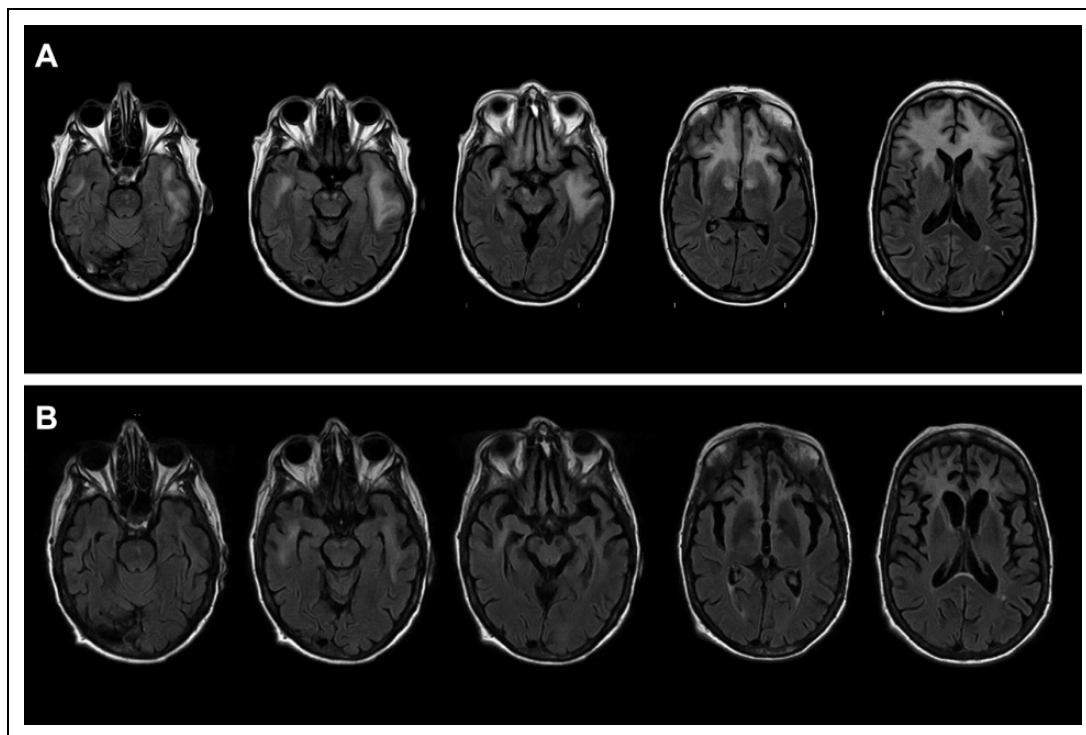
A, MRI brain FLAIR images showing multifocal, nonenhancing (not shown) white matter abnormalities. B, On 4-month follow-up: MRI brain FLAIR images showing significant stabilization/resolution of FLAIR abnormalities with associated atrophy in previously affected areas. FLAIR indicates Fluid-attenuated inversion recovery; MRI, magnetic resonance imaging.
